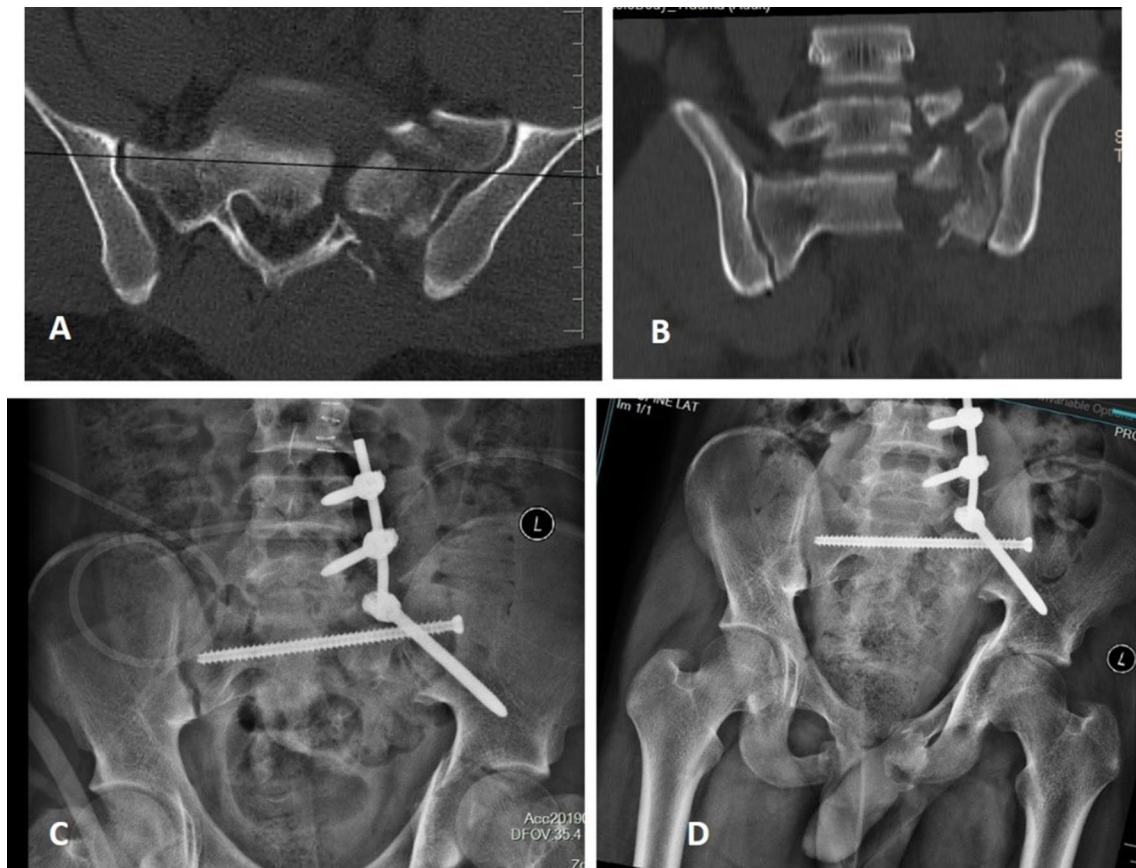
Axial A and Coronal CT images B show a displaced Isler type 2a fracture. The fracture lines are complex and can be seen traversing the S1 facet associated with subluxation. The fracture has been
